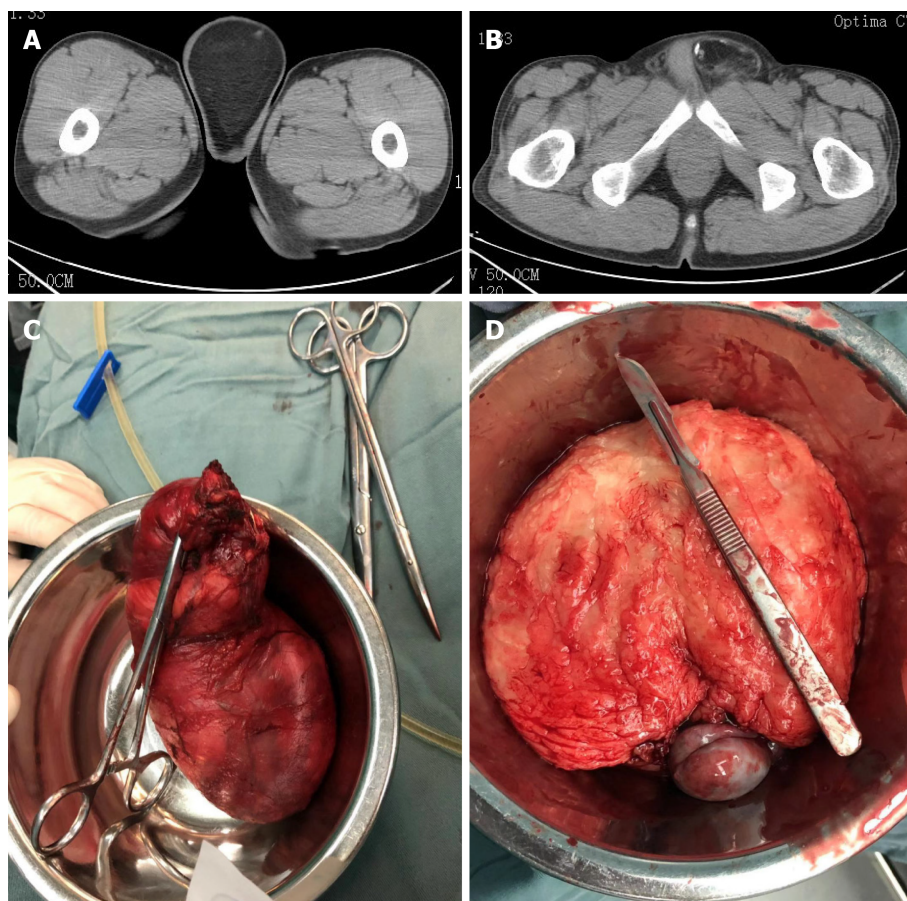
Computed tomography images. A: Computed tomography scan showing spotted and nodular calcification; B: The maximum cross-sectional area was about 8.6 cm × 6.8 cm; C: The giant tumor was a gray-yellow mass, measuring 14 cm × 8 cm × 6 cm, and its capsule was intact and close to the testis; D: The cut plane of the tumor was gray-yellow.
